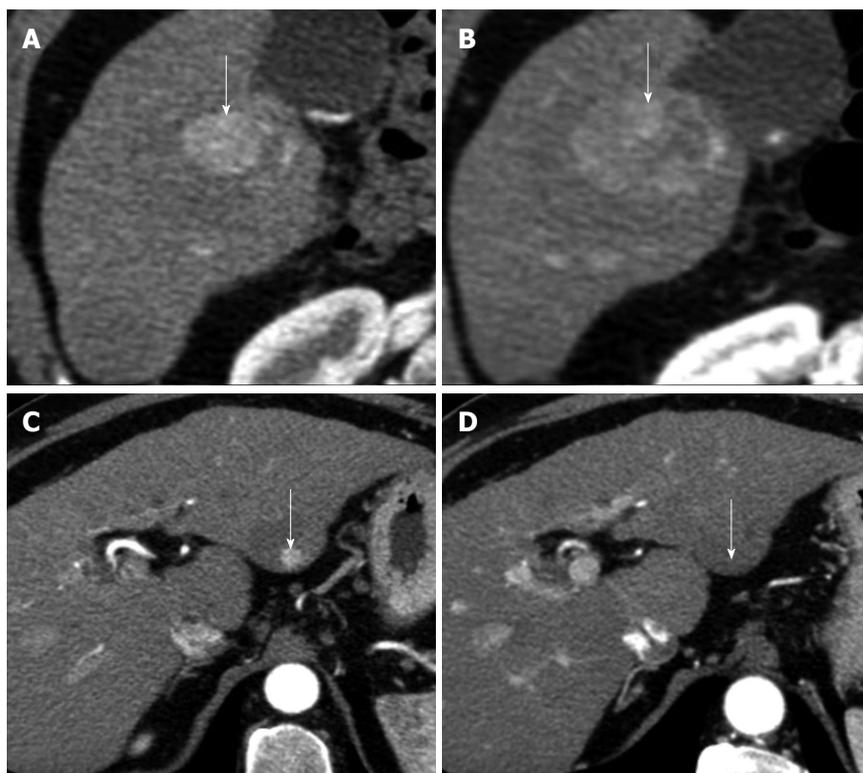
Hepatocellular carcinomas after sorafenib. A: Pretreatment arterial phase computed tomography (CT) shows a large hypervascular hepatocellular carcinoma (HCC) (arrow) in right hepatic lobe; B: Arterial phase CT obtained at the same level of A, 9 mo after the start of sorafenib, shows increase in size of HCC (arrow); C: Pretreatment arterial phase CT image shows a second, small hypervascular HCC (arrow) arising within a larger hypoattenuating dysplastic nodule in left hepatic lobe; D: Arterial phase CT obtained at the same level of C, 9 mo after the start of sorafenib, shows disappearance of HCC enhancement (arrow). This case shows that different HCC response to sorafenib may occur in the same patient.
